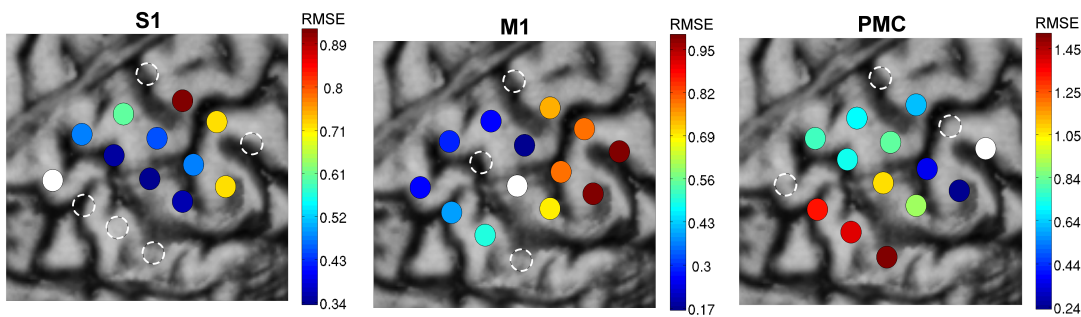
Decoding of the intensity from all recording channels for different positions of the stimulation electrode. Second stimulation session with P1, channel positions are displayed as circles overlayed over the MRI of P1. Left: Stimulation electrode (white electrode) placed over the somatosensory cortex (S1). Middle: Stimulation electrode over M1. Right: Stimulation electrode over PMC. The RMSE of all other recording electrodes is color-coded. White dashed circles denote electrodes which were not used in the analysis, either because of strong stimulation artifacts or because they had been used as the reference electrode.
